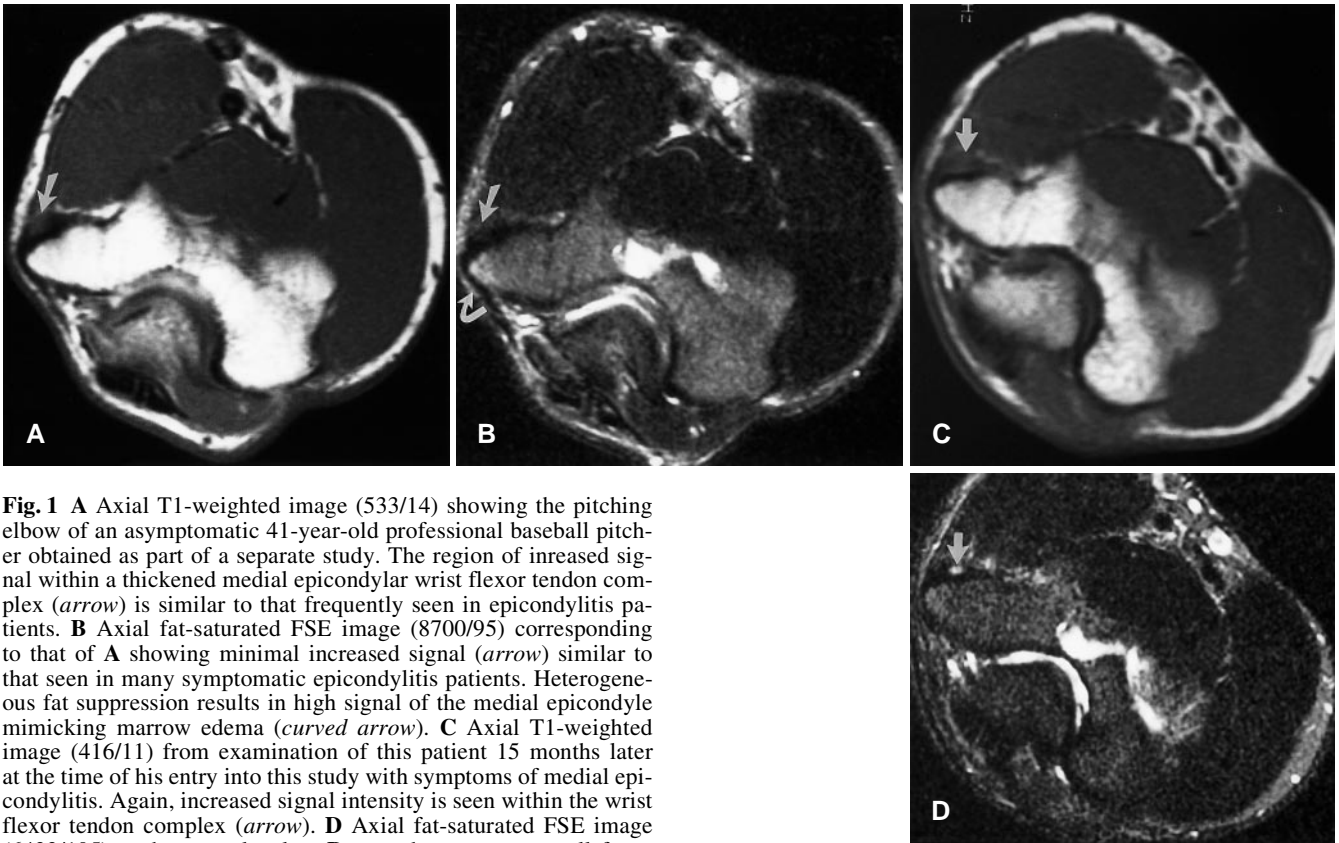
A Axial T1-weighted image (533/14) showing the pitching elbow of an asymptomatic 41-year-old professional baseball pitcher obtained as part of a separate study. The region of increased signal within a thickened medial epicondylar wrist flexor tendon complex (*arrow*) is similar to that frequently seen in epicondylitis patients. B Axial fat-saturated FSE image (8700/95) corresponding to that of A showing minimal increased signal (*arrow*) similar to that seen in many symptomatic epicondylitis patients. Heterogeneous fat suppression results in high signal of the medial epicondyle mimicking marrow edema (*curved arrow*). C Axial T1-weighted image (416/11) from examination of this patient 15 months later at the time of his entry into this study with symptoms of medial epicondylitis. Again, increased signal intensity is seen within the wrist flexor tendon complex (*arrow*). D Axial fat-saturated FSE image (6433/105) at the same level as B now shows a new small focus of intense signal (*arrow*) similar to that seen in six of our epicondylitis patients
